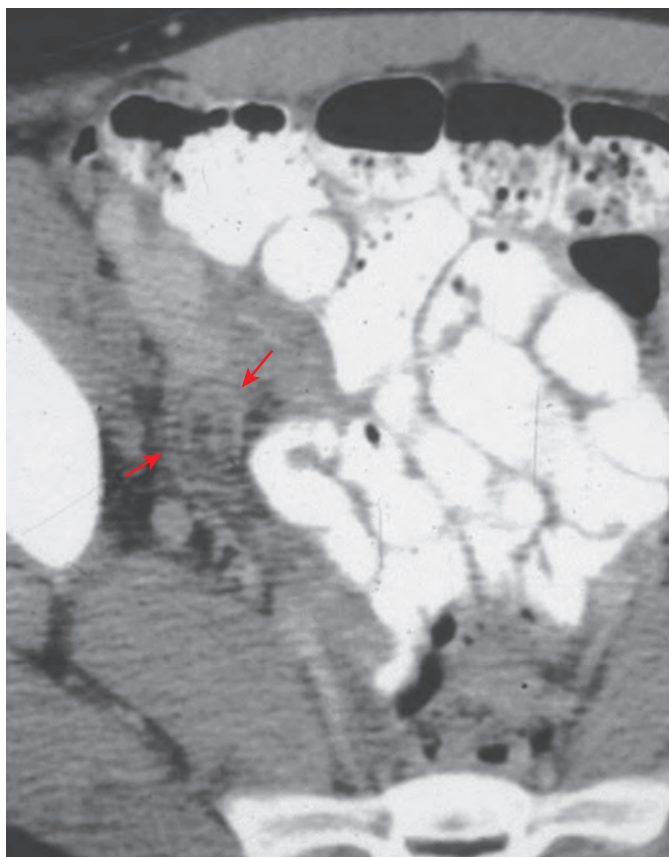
Acute appendicitis. The abnormal appendix (arrows) is seen in cross section on this enhanced CT study, which demonstrates a mural stratification pattern of enhancement with alternating high- and low-density rings caused by serosal and mucosal enhancement and submucosal edema.
